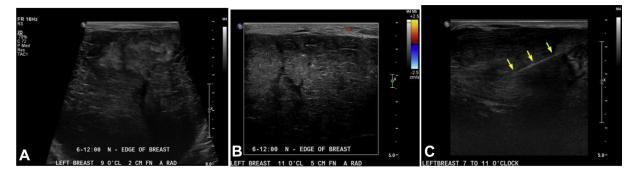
Ultrasound images of mass. (A) Antiradial ultrasound image of left breast mass showing medial half of the left breast is virtually replaced by a large, solid mass with mixed echogenicity. (B) Antiradial Doppler ultrasound image demonstrating the mass is avascular. (C) Unsuccessful aspiration attempt, with needle (arrows) within the solid mass. No fluid or blood was aspirated.
